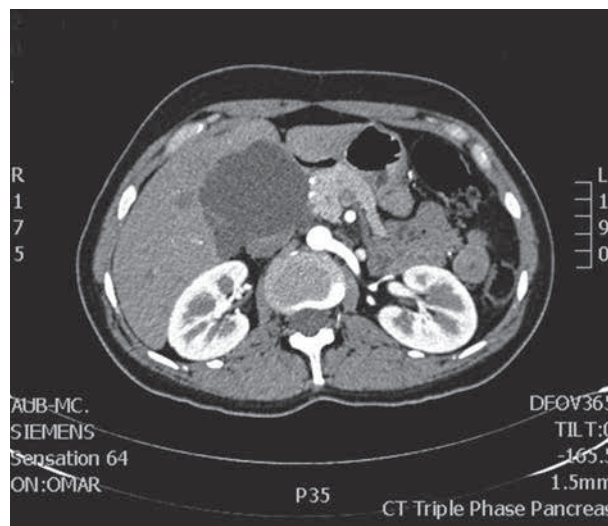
CT of the abdomen showing a right sub hepatic lesion at the time of operation.
